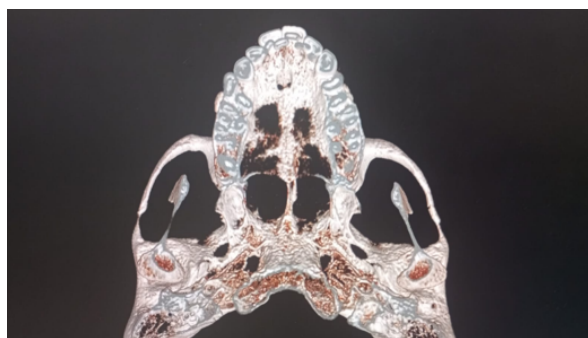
Postoperative computed tomography image demonstrating successful reduction of the left zygomatic arch fracture through a Keen approach.
